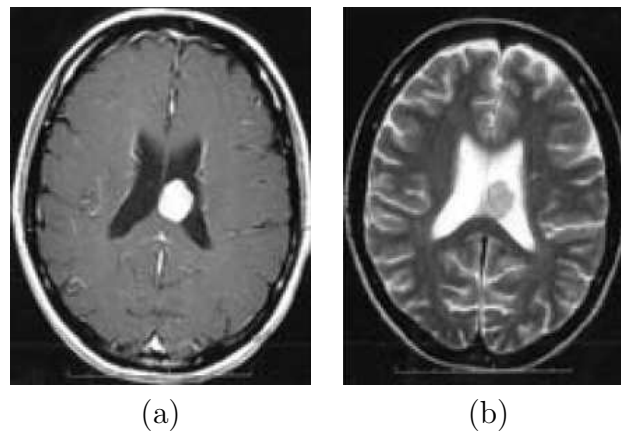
Ependymoma. a) Axial view of contrast enhanced T1-weighted image. b) T2-weighted image of the same tumor [Maksoud et al., 2002].
